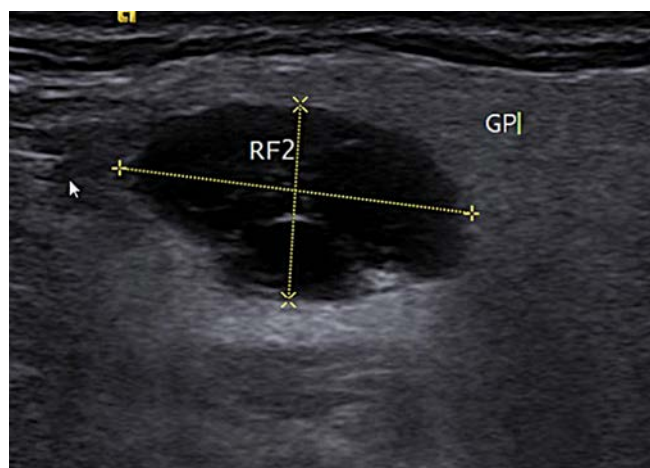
B-mode sonography of the second tumor in the caudal pole of the right parotid gland (2. case, RF2 – second tumor)
